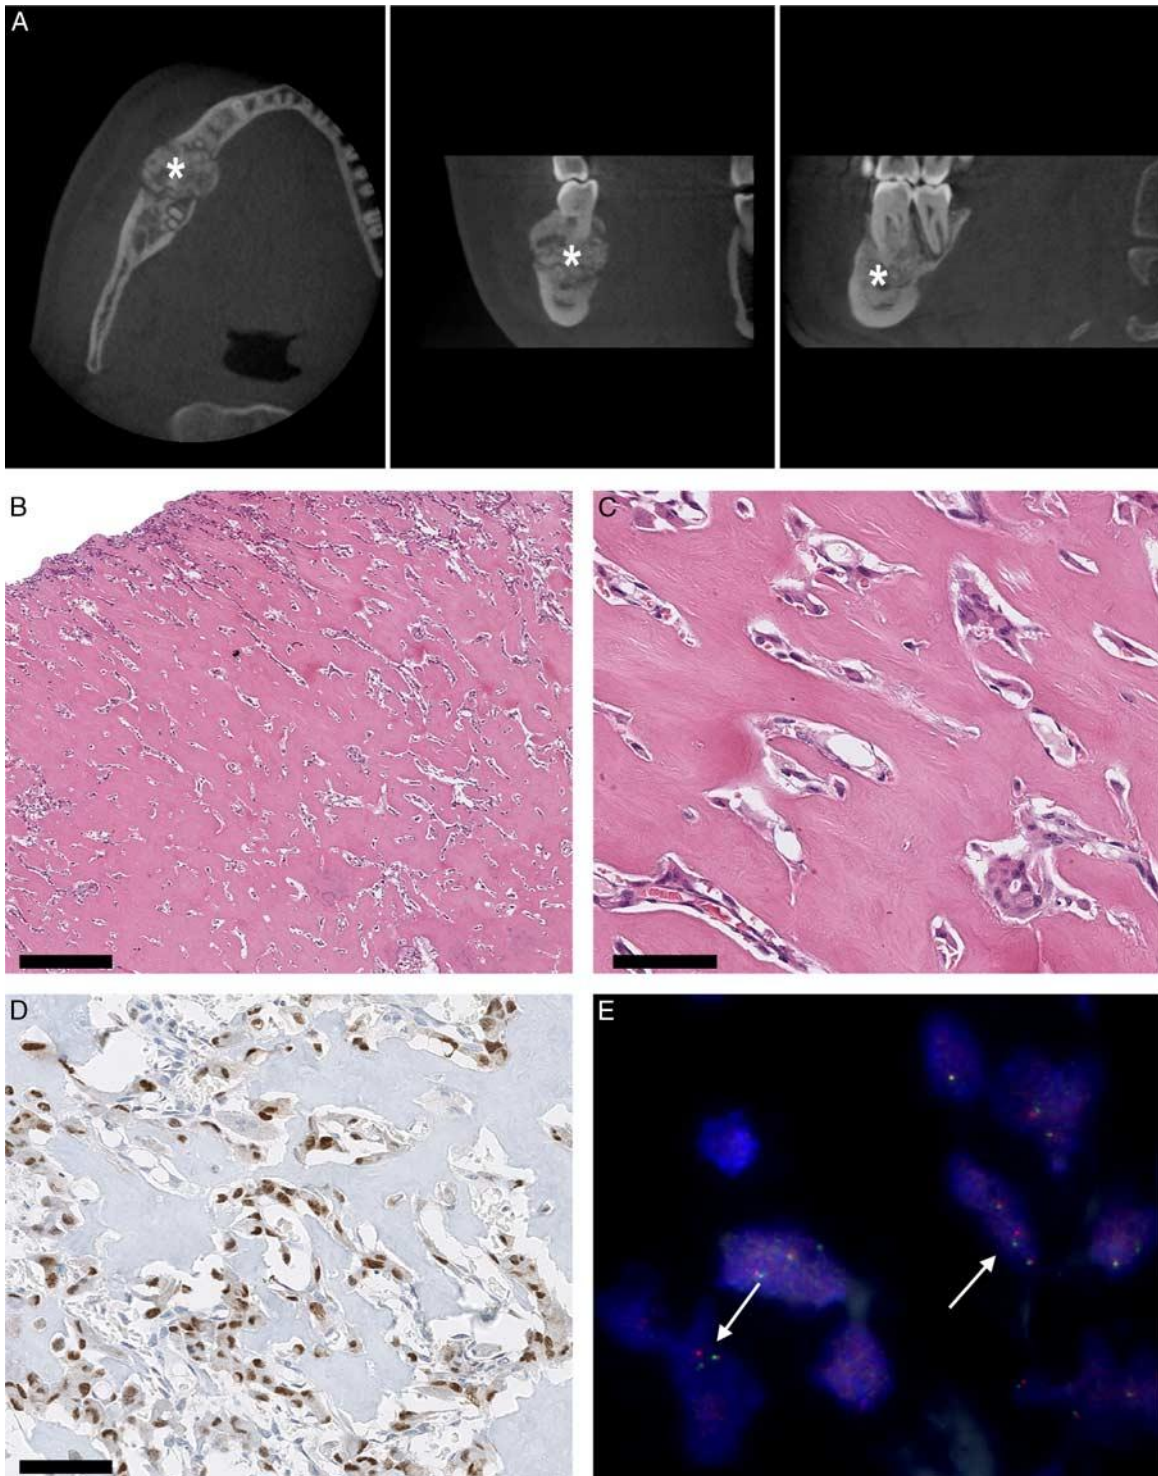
Radiology, morphologic findings, c-FOS expression, and FOS rearrangement in cementoblastoma. A, Computed tomography images show a well-defined lesion (~2 cm) in the mandible on the right side (asterisks). The mass demonstrates an ossifying matrix and is closely related to the root of element 4.6 which shows erosion. There is a cortical interruption on both the buccal as well as the lingual side of the mandible. B, Immature and strongly mineralized matrix formation attached to the root of a tooth. C, Activated cementoblasts and a well-vascularized fibrotic stroma surrounding the lesional bone matrix. D, Strong c-FOS nuclear and cytoplasmic expression in lesional cementoblasts intermingled with negative normal cells. E, FISH using split-apart probes for *FOS* shows a segregated red and green signal in cementoblastoma, indicating a *FOS* rearrangement (arrows).
